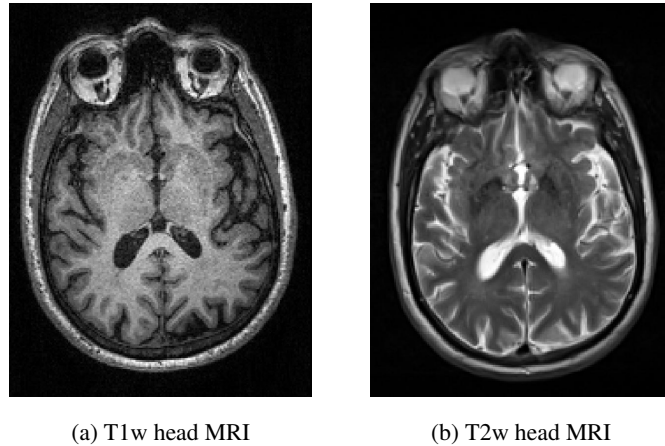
Axial slice of raw T1w (a) and T2w (b) full head MRI of the same subject.
